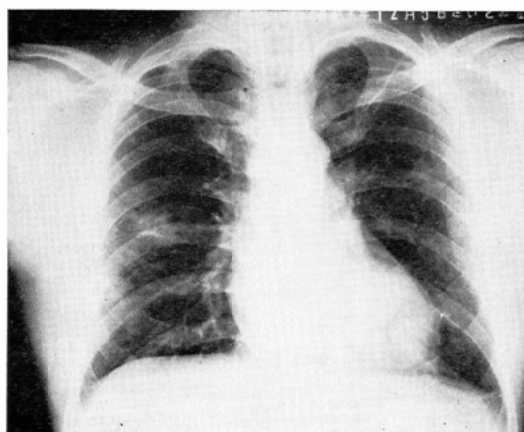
Chest X-ray film following the 2nd FAMT chemotherapy showing only scars in the right apex, right middle lung and the left apex.
